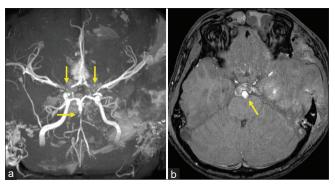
Head magnetic resonance imaging on day 7 revealed bilateral internal carotid artery (ICA) stenosis, basilar artery (BA) stenosis, and pseudoaneurysm at the apical portion of the BA (a and b; yellow arrow).
